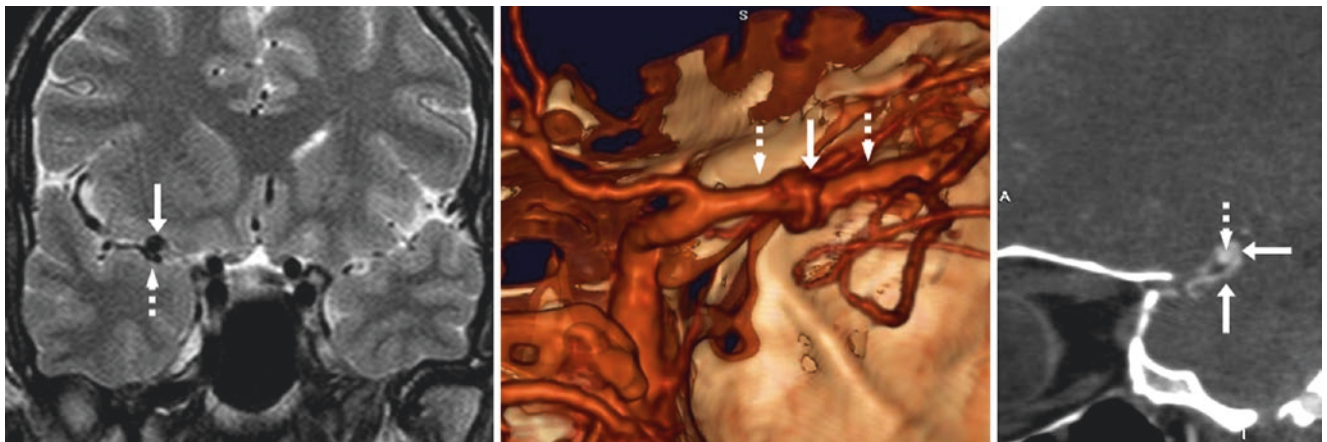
32-year-old with an SMCV (arrows) suspected to represent an aneurysm on coronal T2WI MRI (left). A CTA later showed that the SMCV wrapped around the right MCA (dotted arrows) on a PA view (middle), and on a sagittal MPR (right). Note the difference in contrast
